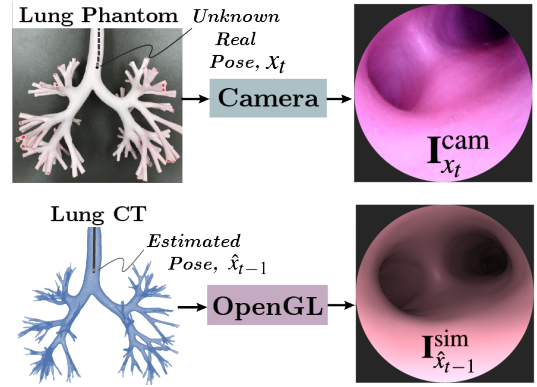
The input to OffsetNet is a $(\mathbf{I}_{x_t}^{cam}, \mathbf{I}_{\hat{x}_{t-1}}^{sim})$ image pair, shown here. A bronchoscope inside the lung generates $\mathbf{I}_{x_t}^{cam}$, and a rendering of the estimated pose in the lung's CT model creates $\mathbf{I}_{\hat{x}_{t-1}}^{sim}$. The task is to identify the offset between them, and through repeated iterations, reduce the offset as much as possible.
